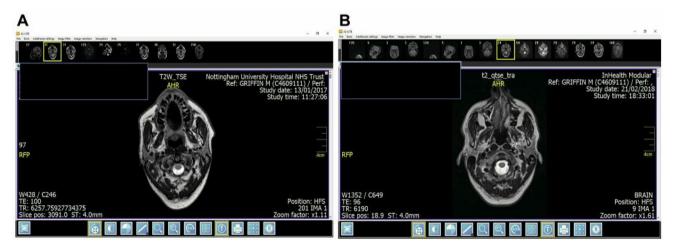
Patient with tanycytic ependymoma. A) A scan on the 13th Jan 2017 showed a reduction in the size and enhancement of the left periventricular tumour. There was almost complete resolution of the parenchymal enhancement with a couple of small ependymal nodules remaining, but slightly smaller. There was no significant change in the T2/FLAIR appearance with Wallarian degeneration extending into the corticospinal tracts. B) A follow-up scan performed on the 21 Feb 2018 revealed evidence of disease progression with a near doubling of the enhancing soft tissue arising from the ependymal surface of the left lateral ventricle and projecting into the body of the left lateral ventricle. There are new enhancing foci in the left putamen and subthalamic region with further non-enhancing T2 hyperintense tumour expanding inferiorly into the left cerebral peduncle.
